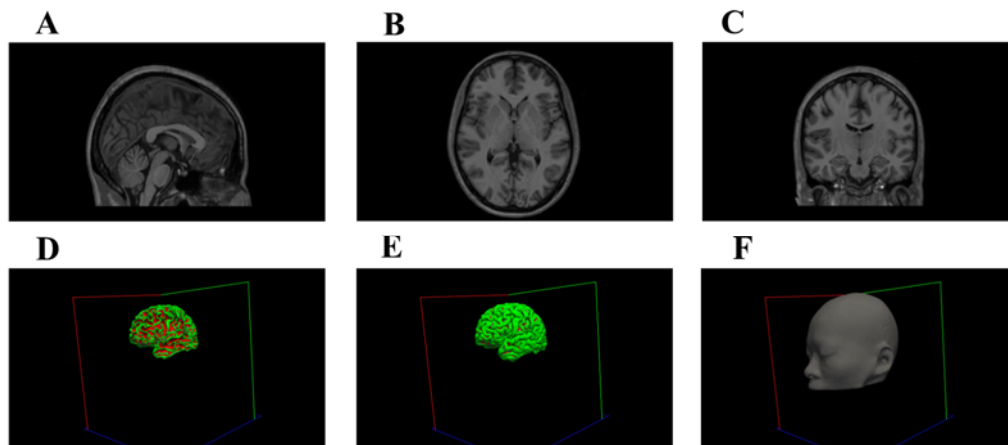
3D brain volume modeling from MR images. A) Sagittal view, B) Axial view, C) Coronal view. The generated WM, Pial surface and head mesh from MRIs are shown in D, E and F respectively.
